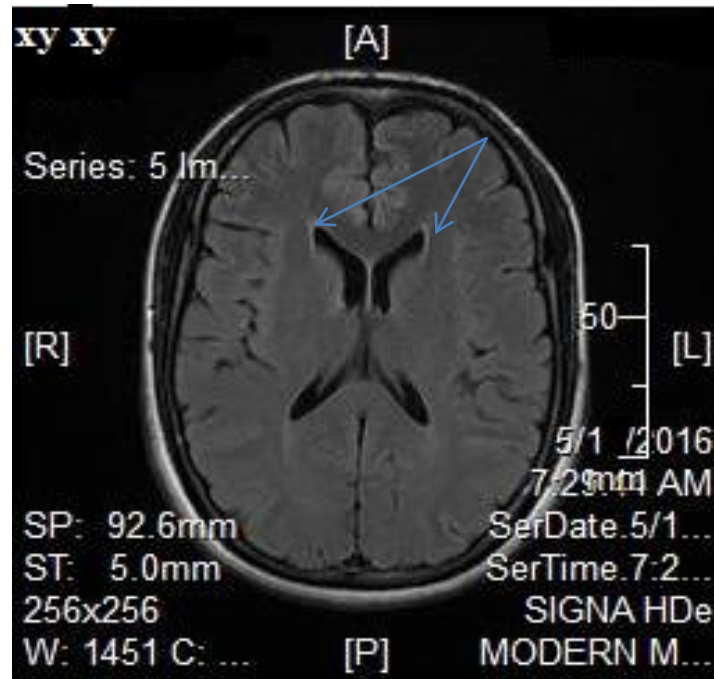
(B.1) shows an axial, FLAIR MR image of forty nine years old male, with a controlled HTN and duration between five to ten years; he had grade one periventricular WMLs (arrows heads) and grade zero deep WMLs.
